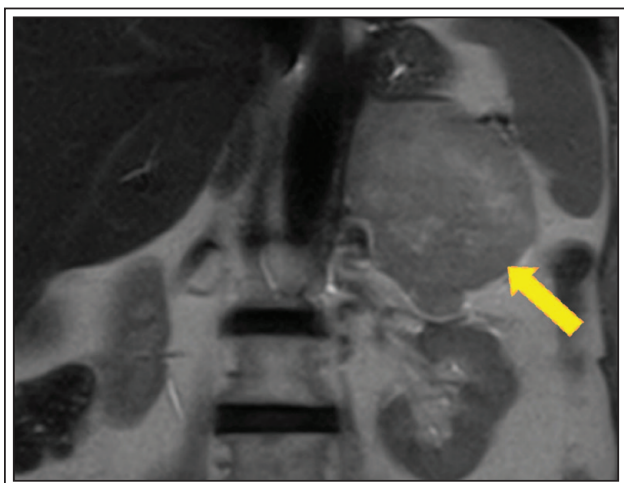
Abdominal MRI (coronal view) revealing left peri-adrenal mass (arrow).
